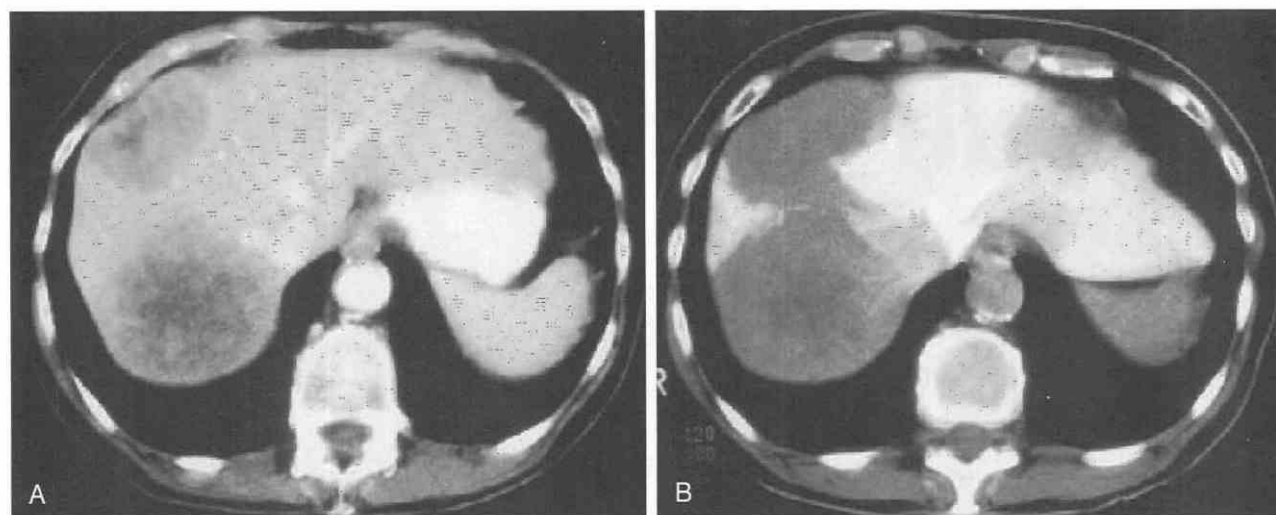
Liver metastases. A, Contrast-enhanced CT scan demonstrates two metastatic lesions in the right hepatic lobe. B, CT arterial portography image shows the same two lesions; however, the presence of a flow-related artifact in the left hepatic lobe suggests a third lesion.
